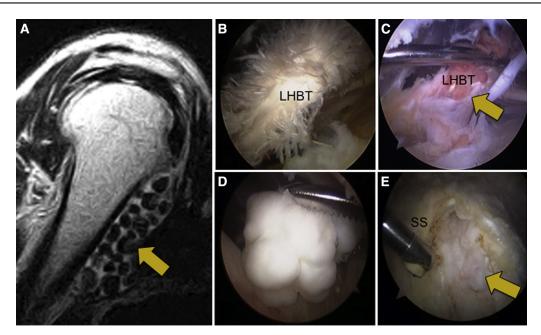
The extra-articular bicipital tunnel is a closed space in which lesions such as loose bodies can aggregate (A, *arrow*) as seen on this sagittal view magnetic resonance image. Several different space-occupying extra-articular lesions have been identified within the bicipital tunnel at the time of transfer of the long head of the biceps tendon (*LHBT*) to the conjoint tendon in symptomatic patients that would not have been visualized arthroscopically, including partial tears (B), adhesion and scar formation (C, *arrow*), loose bodies (D), and osteophyte formation (E, *arrow*). *SS*, subscapularis.
